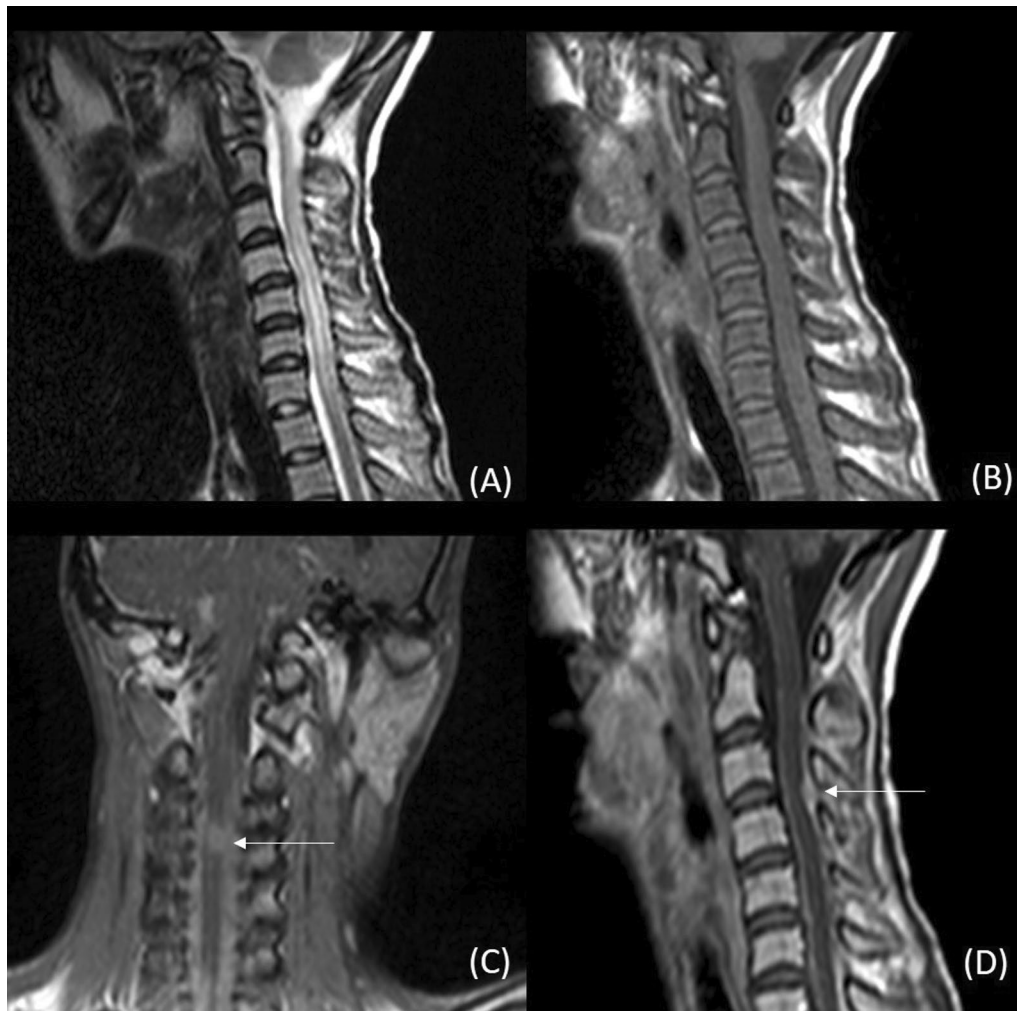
Extramedullary intradural tubercular granuloma with cord oedema. MRI of a 32-year-old female shows cord expansion with high signal intensity in the cord from C3 to C7 vertebral levels, suggestive of cord oedema on sagittal T2W image (A), T1W image also shows cord expansion at the same level (B), T1 contrast-enhanced images show a well-defined peripherally enhancing extramedullary intradural lesion posteriorly at C3–C4 vertebral level (white arrow in C and D)
